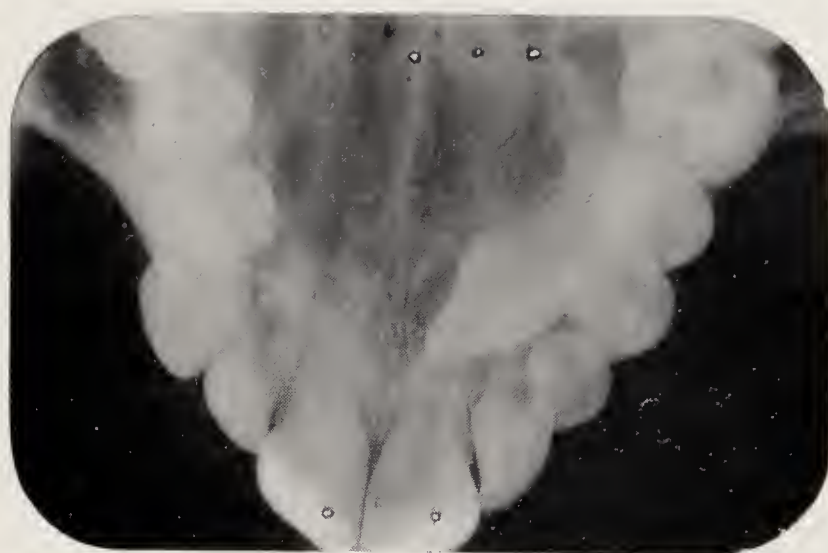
Radiographs to show result of treatment to move $\bar{3}$ into position. The impacted tooth was horizontally placed and on the palatal aspect of $\bar{2}$. Tooth was pinned from the palatal side and moved into position.
